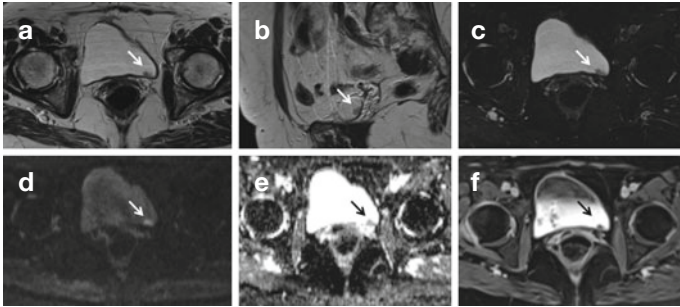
A hypo-isointense lesion (*white arrow*) located on the left side of the bladder, evaluated in T2-weighted imaging (a, b) with also fat signal suppression (c). The neoplasm shows a remarkably high value (*white arrow*) in diffusion imaging (d) which correlates with low ADC values (e), highlighting a tissue with high cellularity (*black arrow*). The mass has no postcontrast enhancement (f), showing a hypointense pattern (*black arrow*)
